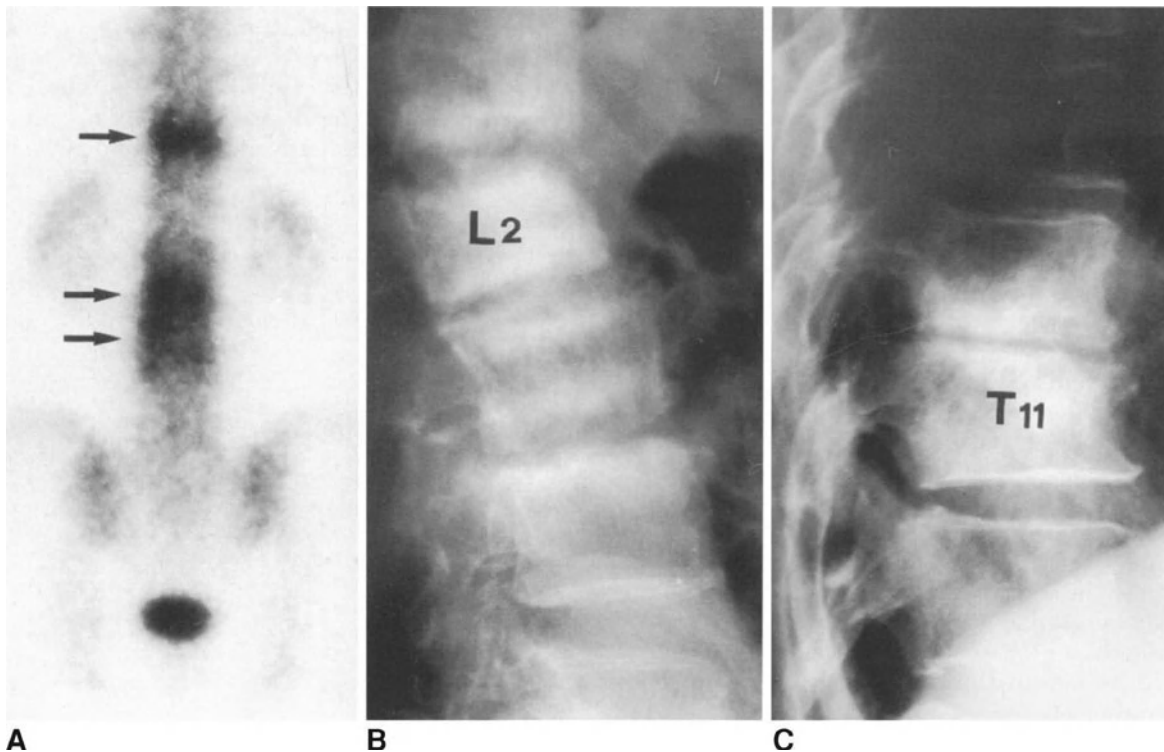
Patient submitted to laminectomy at L2-L4 levels and discectomy at L2-L3 with postoperative plurisegmental spondylodiscitis and diffusion of the infective process to the thoracic spine. Radiographs were negative 25 days after surgery while TC 99 bone scan (A) showed an increased uptake at L1-L3 and T10-T11 levels (arrows). Sixty days after surgery (B), radiographs showed spondylodiscitis at L1-L2, L2-L3 and L3-L4 levels with destruction of the anterosuperior aspect of the L2 vertebral body, resulting in segmental kyphosis at L1-L2 level. At T10-T11 level (C) a marked reduction in the disc height with irregularity of the vertebral end-plates and subchondral bone sclerosis were present.
